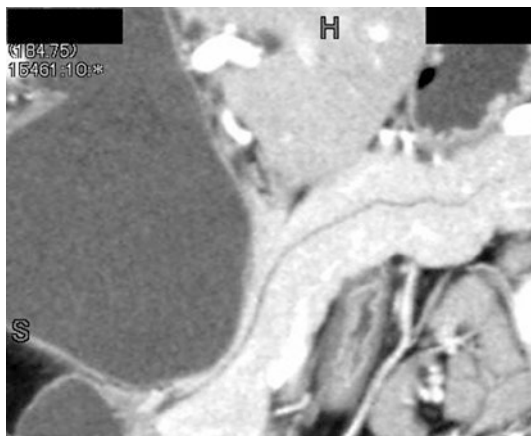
MD-CT image of pancreatic duct type
